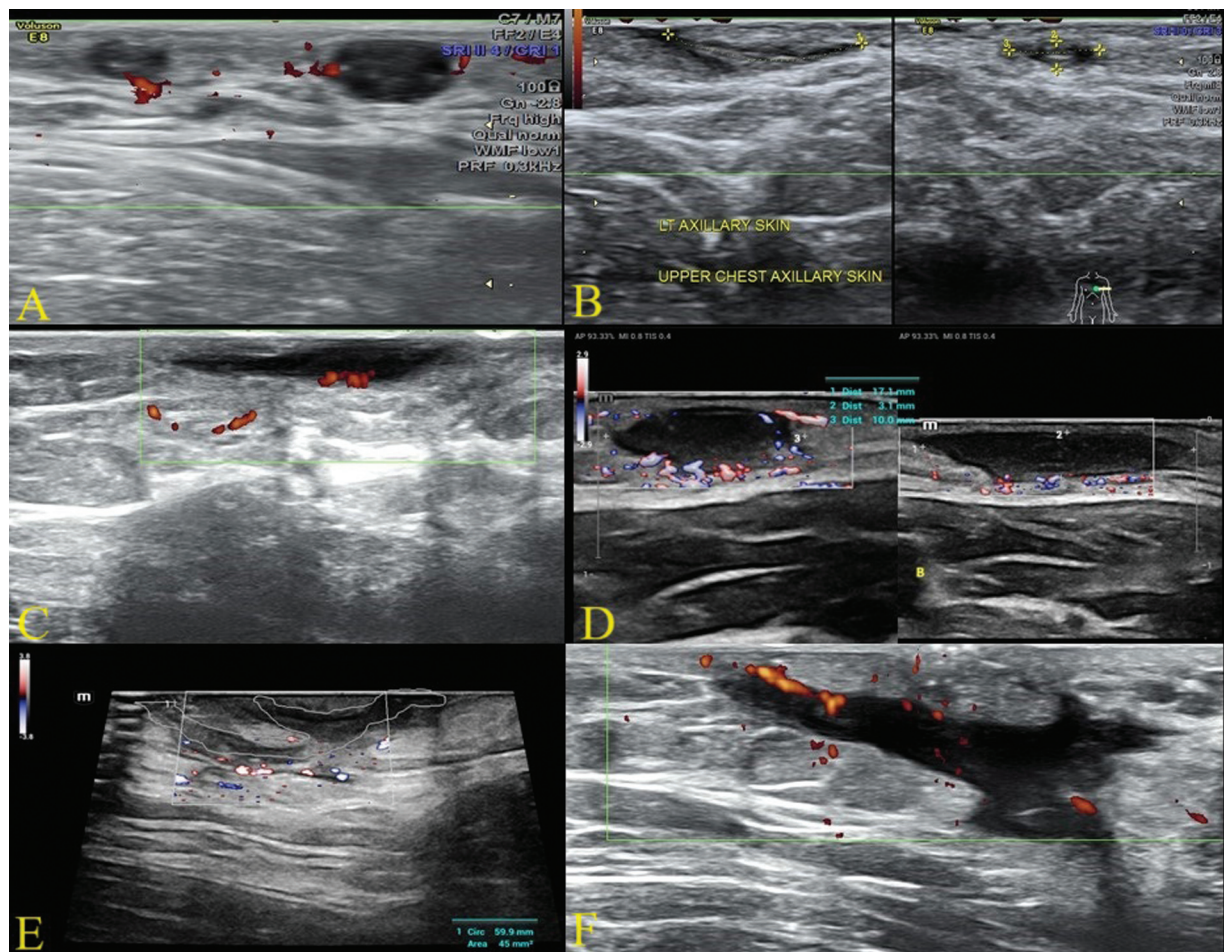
Ultrasound findings in hidradenitis suppurativa. (A) Dermal pseudonodules. (B) A thickened hair follicle with images showing the length and breadth of the hair follicle. (C) A dermal fluid collection. (D) Dermal abscess with increased vascularity. (E) An interconnecting fistula in the dermis connecting the base of many hair follicles. (F) An interconnecting fistula extending into the subcutaneous tissue.
